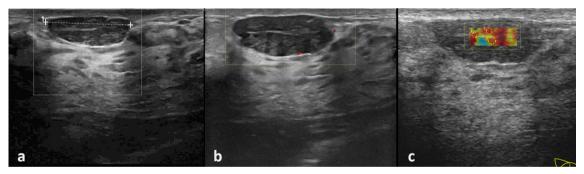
(a) Ultrasound image of retroareolar mass of the same patient. (b) Lesion had interval enlargement within one-year clinical follow-up, and was therefore sampled. Pathological diagnosis was consistent with fibroadenoma. (c) Shear-wave elastography of the lesion.
